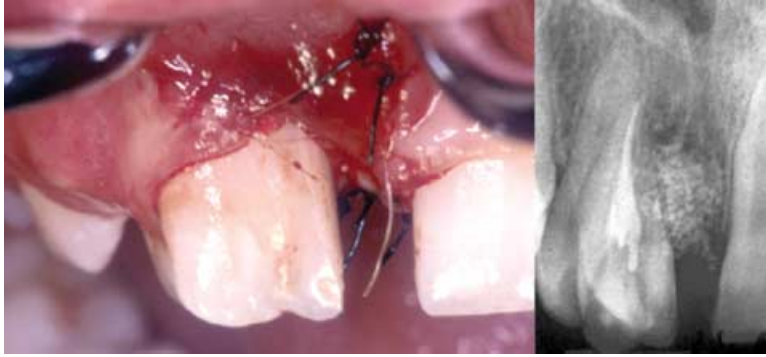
Clinical photograph and radiograph taken immediately postsurgically. The defect left by the extraction of the mesial tooth is filled with beta-tricalcium phosphate ceramic.
